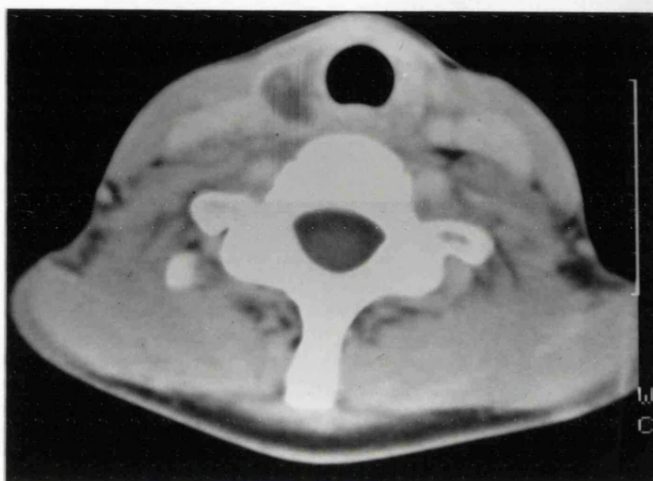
CT scan showing infarction of right thyroid lobe following radioiodine ablation.
